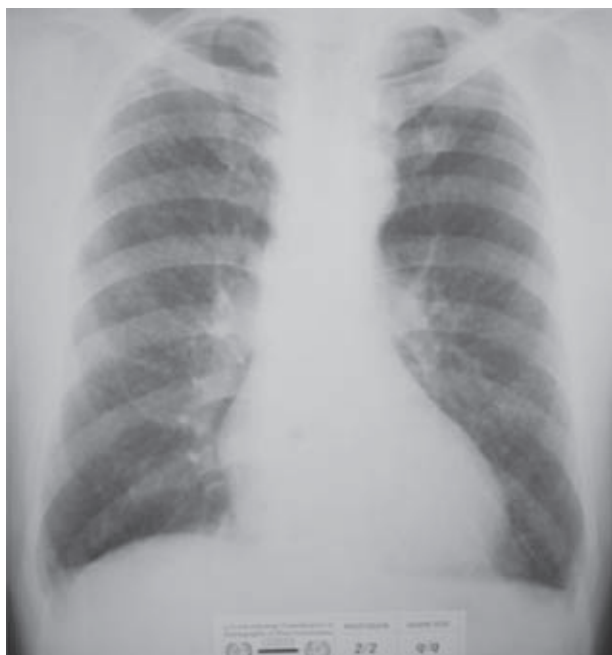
Typical 1.5–3 mm in diameter rounded opacities of chronic silicosis predominantly in the upper zones of the lungs. The radiograph is from the set of International Labour Organization (ILO) standard films. International classification of radiographs. Reproduced with the kind permission of the ILO. Copyright © 2000 International Labour Organization.
